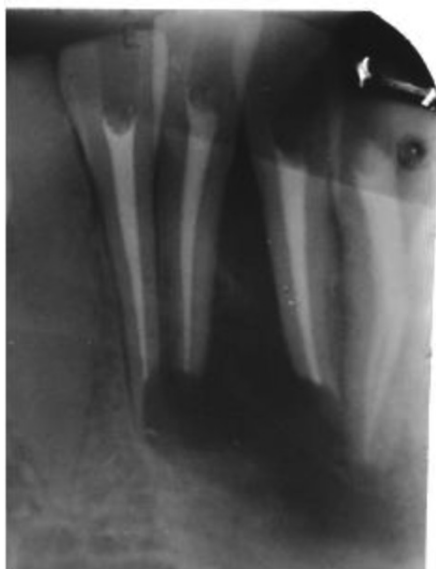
Immediate Post-operative radiograph showing apicectomy done wrt 32,31,41,42.
